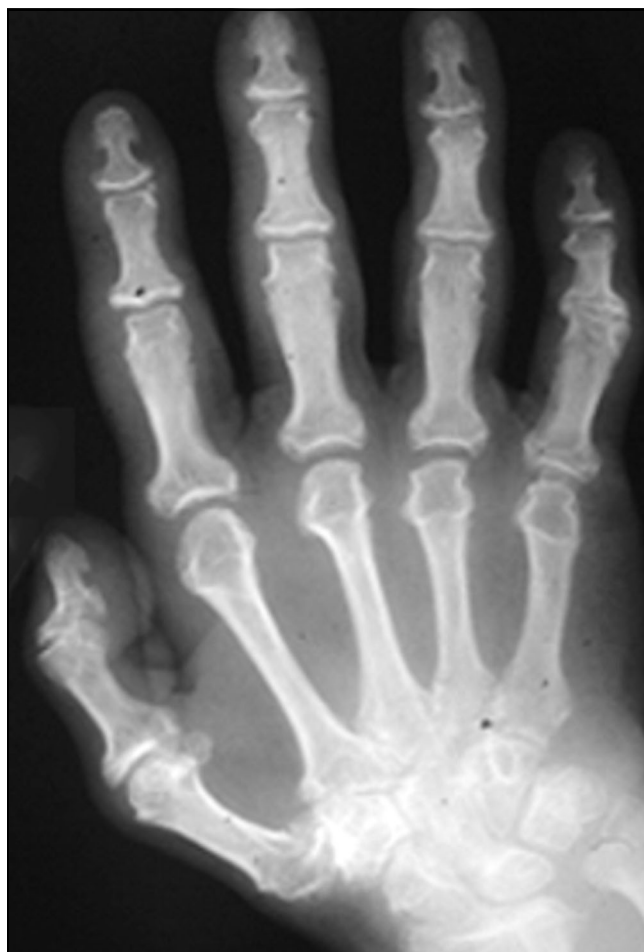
Radiograph of a hand in moderately advanced acromegaly showing a mixture of joint space enlargement and degenerative changes.
